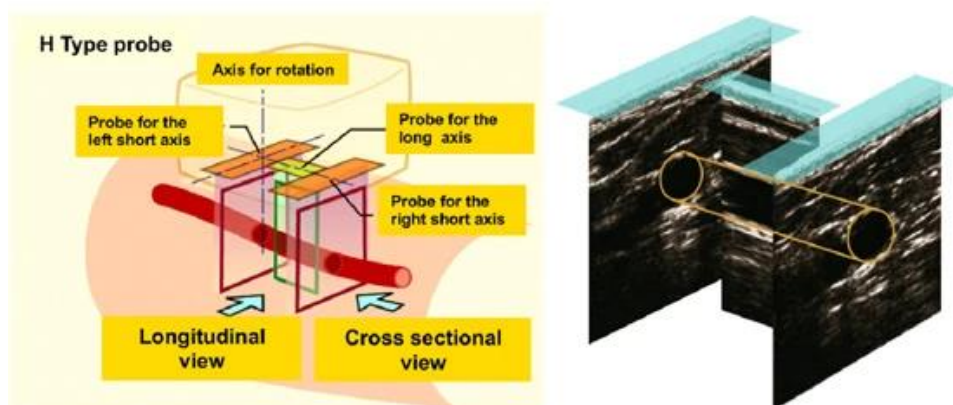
UNEX H-shaped probe displays longitudinal and cross-sectional ultrasound images simultaneously. Reproduced from Iguchi, T., Takemoto, Y., Shimada, K. et al. Simultaneous assessment of endothelial function and morphology in the brachial artery using a new semiautomatic ultrasound system. *Hypertens Res*, 2013; 36, 691-697.
